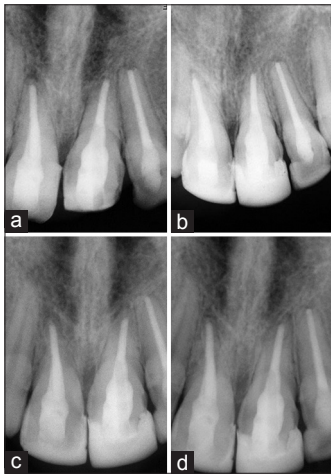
Post-treatment and follow-up radiographs. (a) The radiographic image after the root canal treatment was completed. (b) The radiographic image 15 months after replantation. (c) The radiographic image 21 months after replantation. (d) The radiographic image 27 months after replantation.
